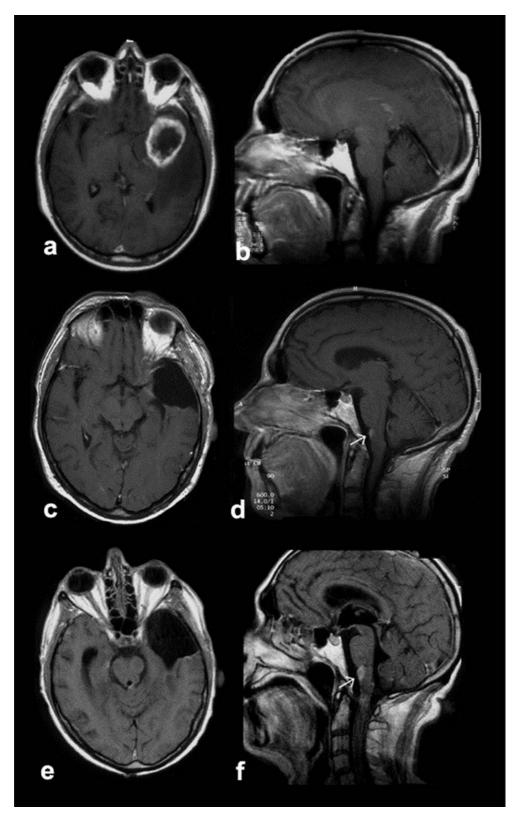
Contrast-enhanced MRI of a 63-year-old male patient (Table II, pat. no. 52) showing a typical glioblastoma in the right temporal lobe (a). The brainstem showed no evidence of tumor invasion (b). Ten weeks after gtr, no local recurrence was detected (c). However, in the anterior brainstem, a small contrast-enhancing lesion had developed (\rightarrow , d). A control MRI 24 weeks after surgery confirmed sustained local tumor control (e), but a progress of the brain stem lesion (\rightarrow , f).
